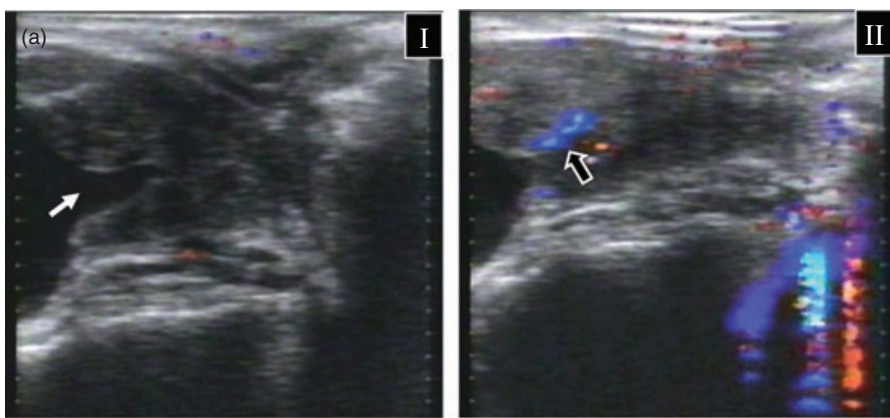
Color Doppler ultrasonographic images of ejaculation in case 2. (a) With oral silodosin. (I) Significant opening of bladder neck (white arrow). (II) A small amount of seminal fluid flows into the bladder (black arrow). (b) Without oral silodosin. (I) Bladder neck (white arrow) does not open. (II) Spurting stream (black arrow) from the seminal vesicles (*sv*) towards the bulbous urethra (*bu*) through the ejaculatory duct (*ed*).
